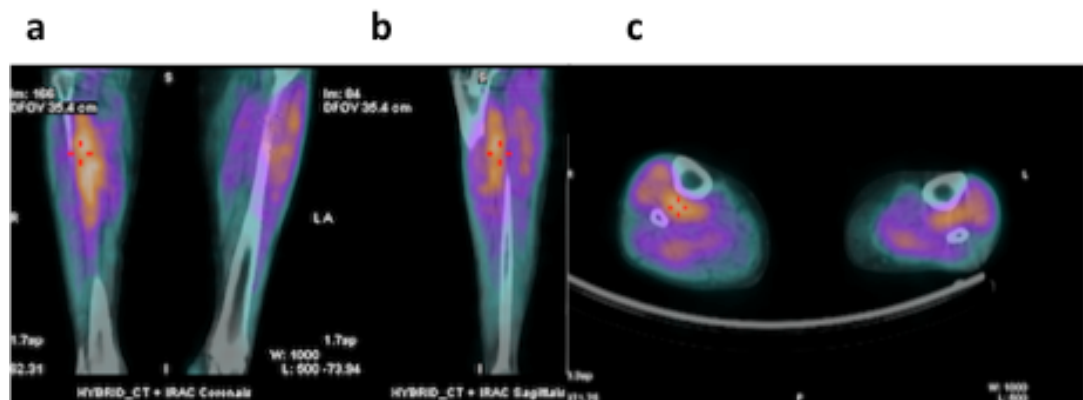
Hybrid SPECT/CT cross-sectional images of the calves of Patient E at stress. Panel a (coronal section), b (sagittal section), and c (axial section).
